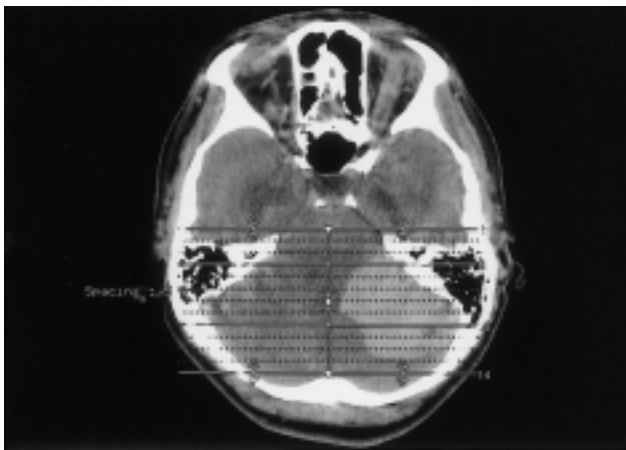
Computed tomography reveals an amorphous and well-margined low-attenuation lesion located in the left cerebellopontine angle.
